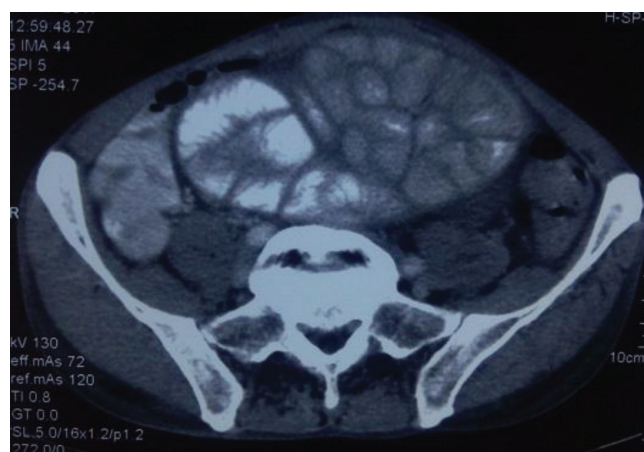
CT showing encapsulating fibrous membrane surrounding intestinal loops
